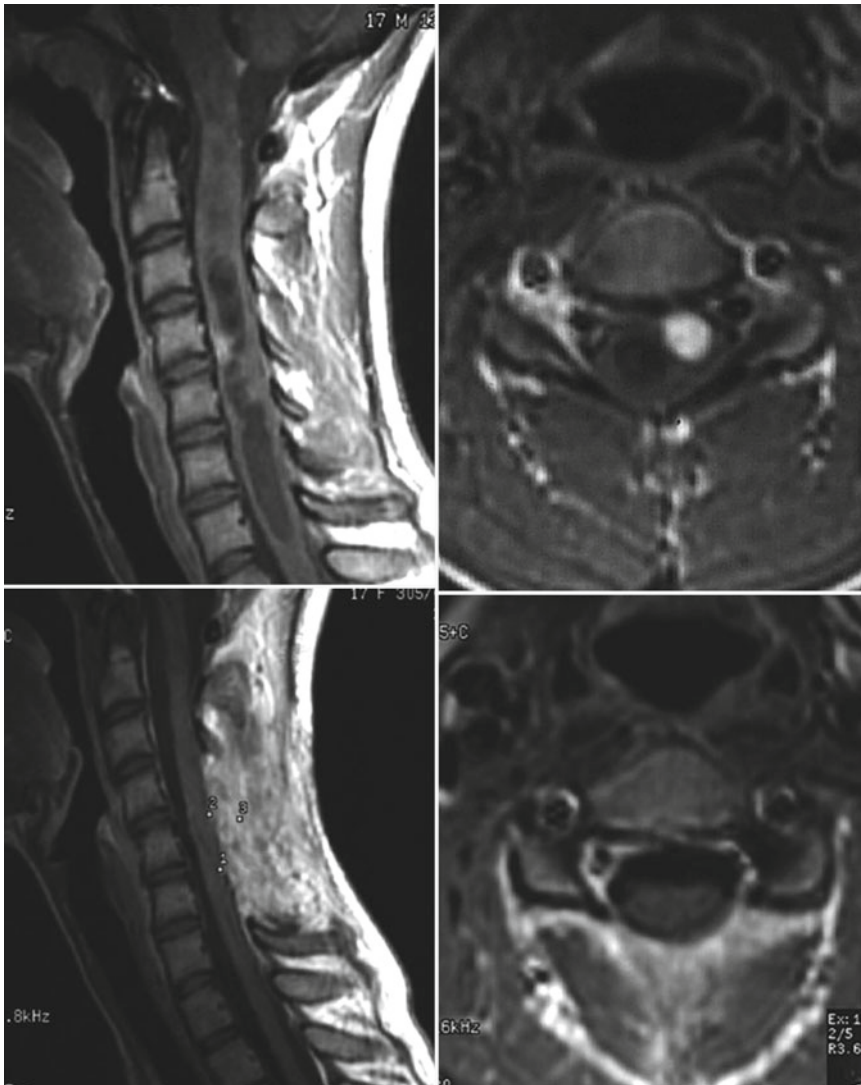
Grade II intramedullary astrocytoma. Contrast enhanced MRI showing an intramedullary cystic lesion with an enhancing nodule. Preoperative (*upper row*) and postoperative scan confirming gross total resection (*lower row*)
